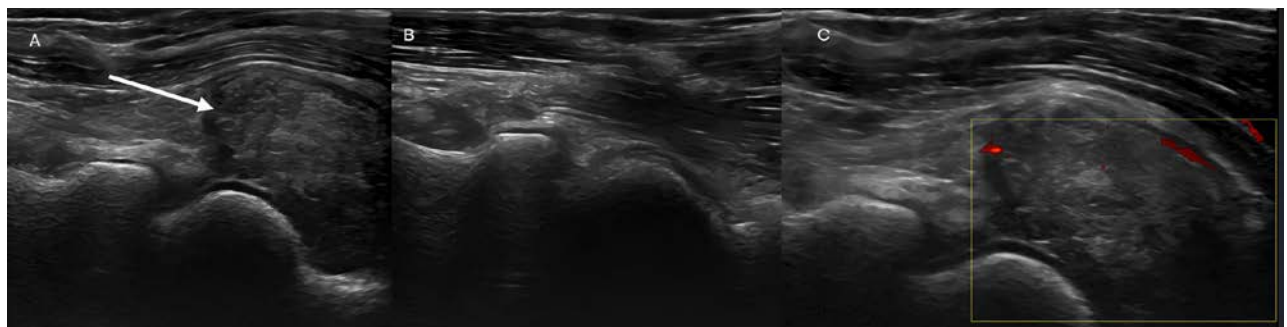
Ultrasound of the elbow demonstrates localized intra-articular TSGCT in the anterior fat pad of the elbow (arrow). The lesion appears as a well-defined hypoechoic nodular synovial mass (A) with intralesional vascularity on colour Doppler (C). There is no significant intra-articular fluid.
